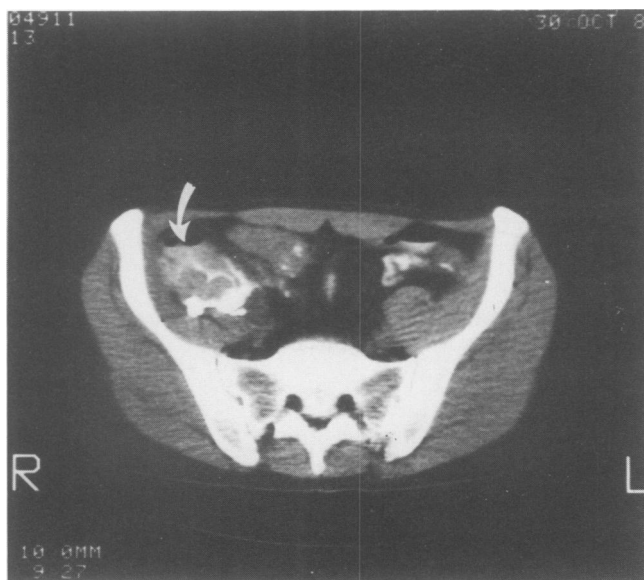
CT scan clearly defines retroperitoneal abscess (arrow) from Crohn's disease that tracked down the psoas muscle into the groin.
